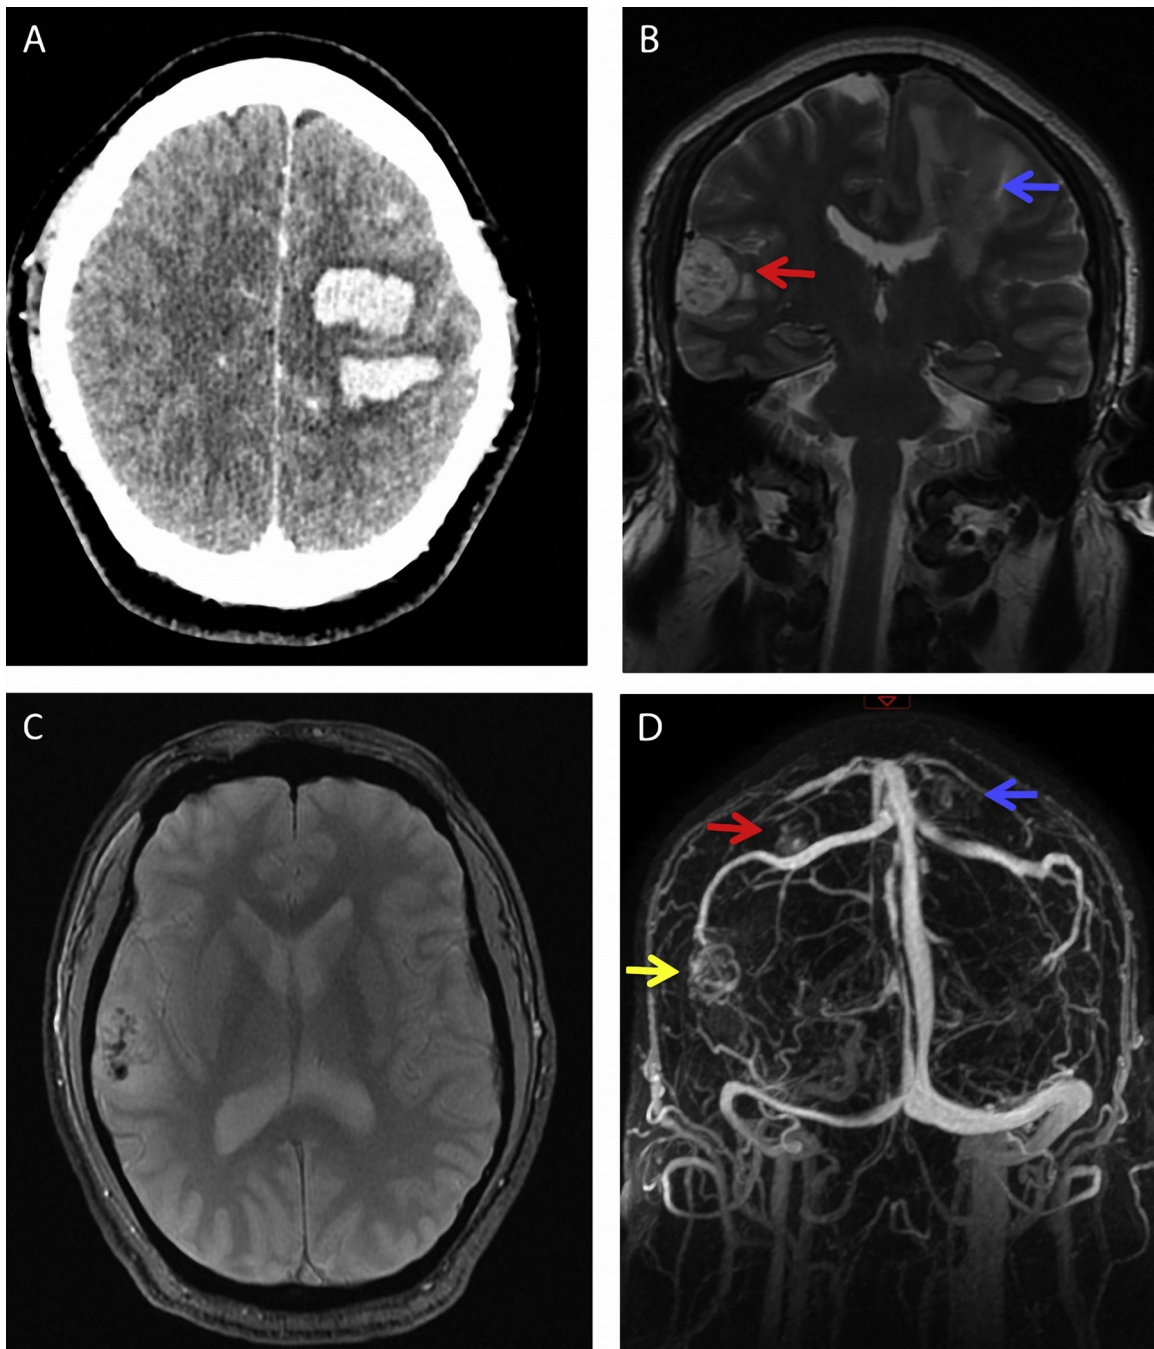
A) Simple axial computed tomography showing a hemorrhage located in the left hemisphere from the semioval center to the middle frontal, pre-, and post-central gyri. B) Magnetic resonance imaging (MRI) T2 showing two lesions: 1) a heterogeneous lesion in the right superior and middle temporal gyri (red arrow); and 2) a hemorrhagic lesion with edema in the pre- and post-central gyri on the left side (blue arrow). C) MRI T2 gradient-echo showing a lesion located in the temporal lobe, with tubular forms lacking signal. D) MRI showing three vascular lesions (yellow, red, and blue arrows) with afferent vessels (arteries) and efferent vessels (veins).
